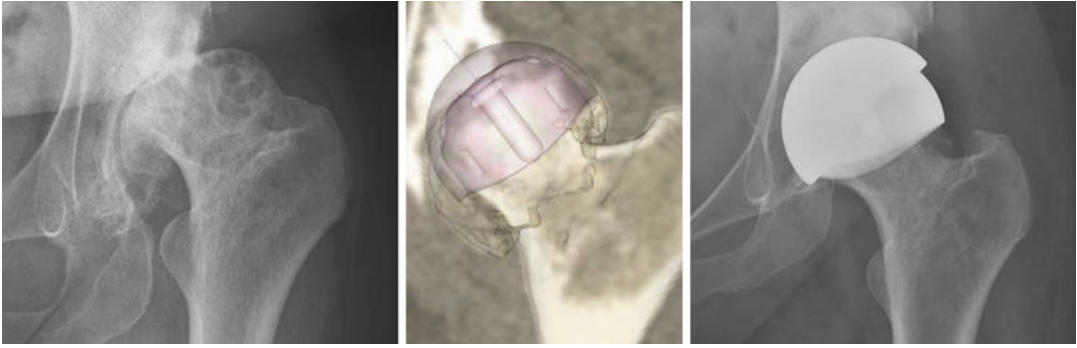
A 50-year-old woman had painful osteoarthritis secondary to Crowe II DDH. Preoperative radiograph. Planning with acrylic templates of H1 resurfacing. Post-operative 6-month radiograph
